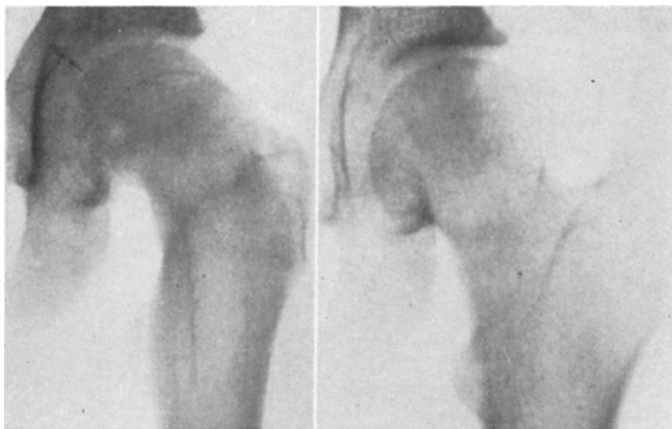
Case x. Roentgenogram August 1, 1933; marked destruction in the neck; definite slipping of the head.
